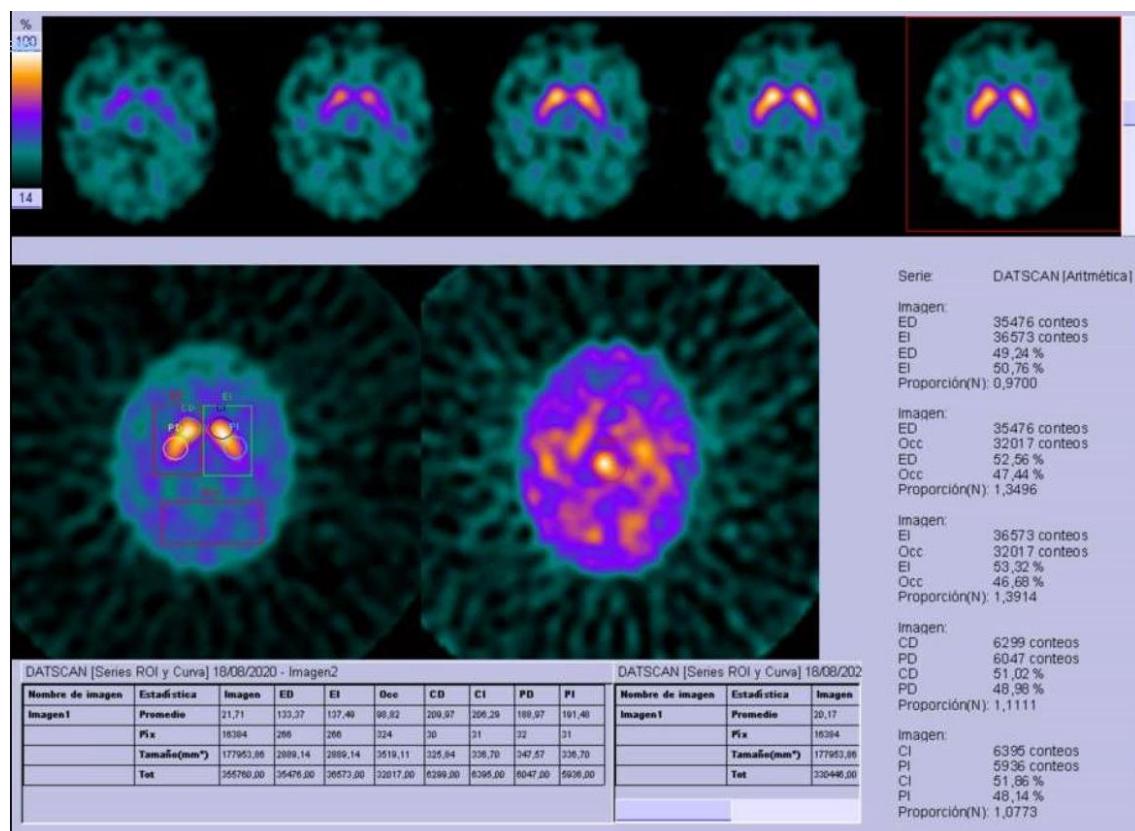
Cuantificación SPECT [^{123}I]-loflupano en sujeto sano.
